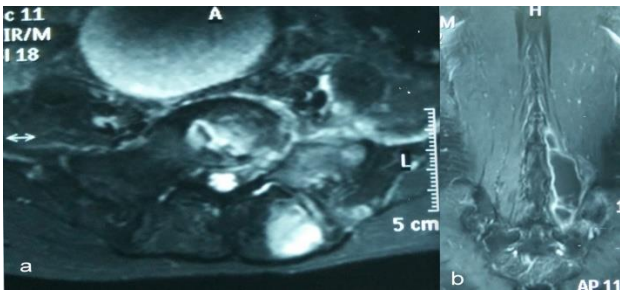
MRI of the sacrum showing sacral destruction with presacral (a) and paraspinal abscess (b).
